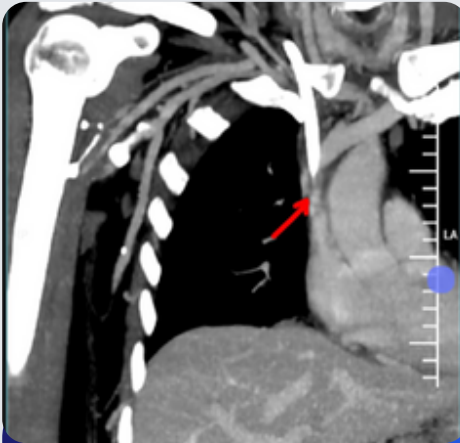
CT showing Stenosis of Central Vein
